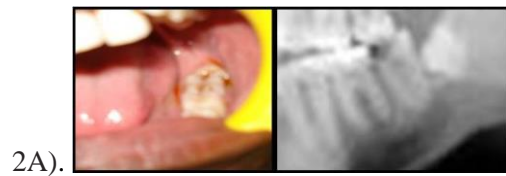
clinical and radiographic view of 37 and 38
